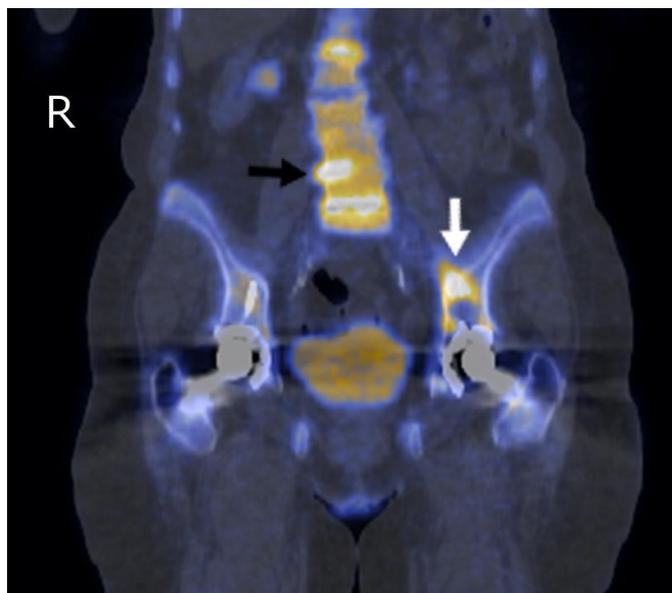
An 80-year-old female with particle disease. This coronal view of a fusion 18F-Fluoride PET/CT demonstrates the particle disease superior (white arrow) to the left acetabular joint. No activity is seen in the erosive lesion in which the screw of the prosthetic lies. Infection might appear similar on PET/CT but was better ruled out with the 3-phase bone scan. Arthropathic changes and uptake (black arrow) are noted in the spine. We noted that activity is only localized to the joint spaces which is uncharacteristic of metastases. [Helical CT set at 120 kVp and auto mAs on a 16-slice scanner, axial plane, no IV contrast. Acquired for 35 minutes after waiting 1 hour post IV injection of 15.5 mCi F-18 sodium fluoride via a right antecubital vein]
